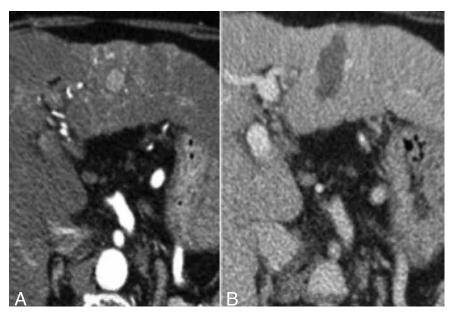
CT examination berore treatment did assess the presence of a small HCC within segment III (A). CT evaluation 1 month after microwave ablation did show a complete ablation area, larger that target lesion (B), suggesting complete response to treatment.
